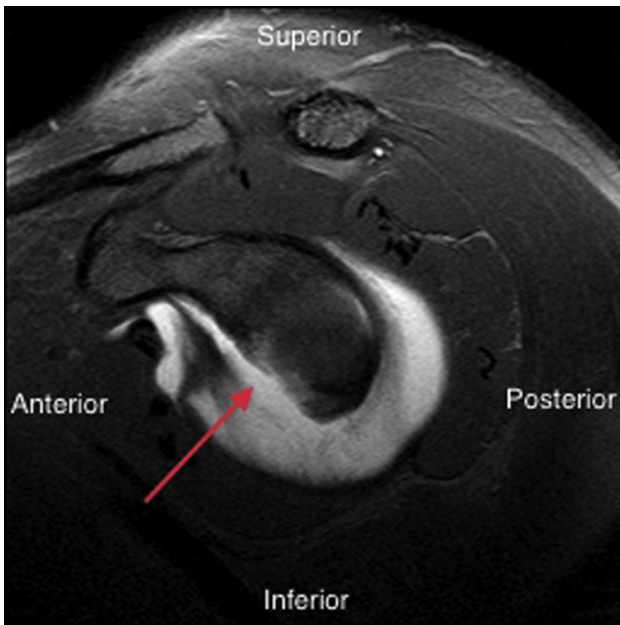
Pre-Latarjet preoperative sagittal magnetic resonance image showing extent of anterior glenoid bone loss. *Arrow* indicates the anterior glenoid bone loss.
